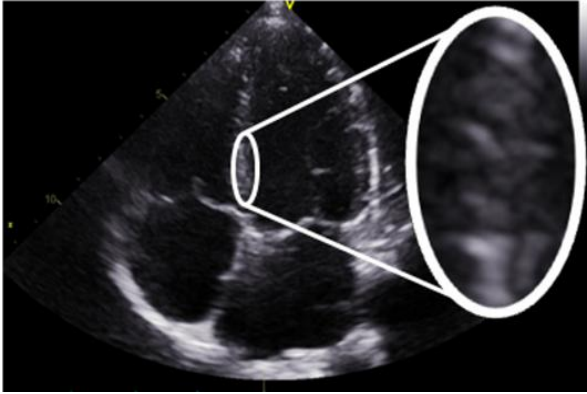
Zoom of the interventricular septum (2D echocardiography, 4-chamber view) where myocardial speckles can be observed.
